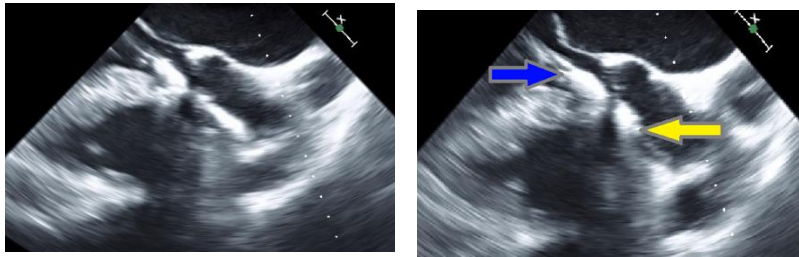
implantation of balloon expandable TAVR in a systematic two-steps approach; (a) positioning step and (b) full deployment step under TEE and radiographic guidance*
